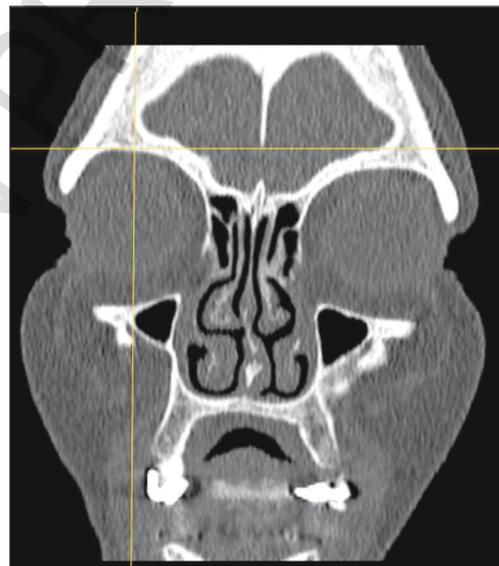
Coronal CT image demonstrating FSH with supraorbital and midorbital reference lines
